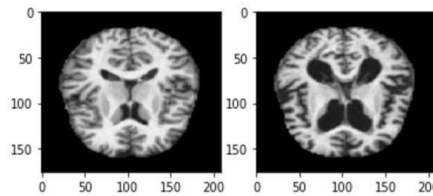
MRI Images from the Dataset of the Brain.
